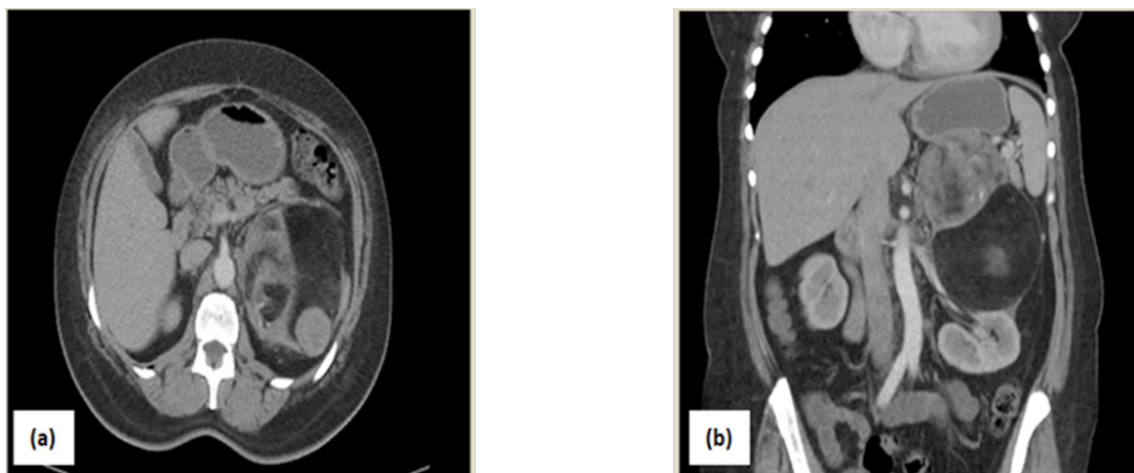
Computed tomography (CT) scans. (a)CT shows a heterogeneous mass with lobular contour and soft tissue areas, (b)This mass was extending to the stomach and spleen at the top and compressing the left kidney at the bottom
